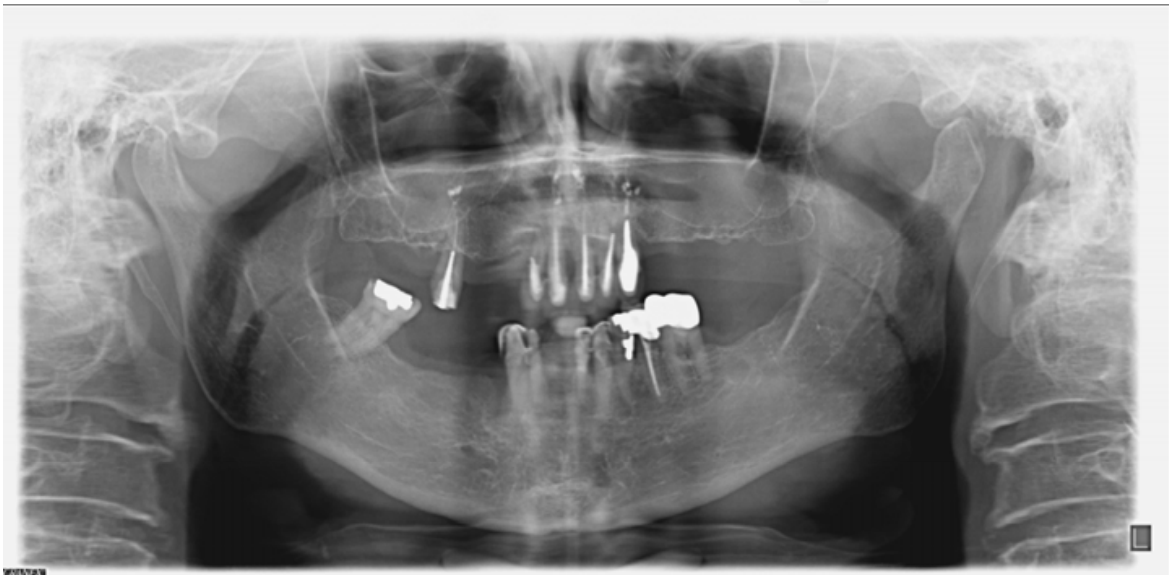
Initial radiograph before surgical treatment
